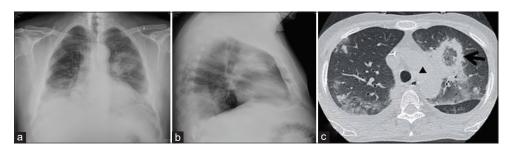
A 53-year-old male presenting with fever and dyspnea. (a and b) Chest X-ray demonstrating bilateral pulmonary infiltrates more prominent in the left upper and the lower lobes. (c) Chest computed tomography demonstrating reversed halo sign in the left upper lobe (arrow), patchy bilateral infiltrates, and bilateral pleural effusions.
